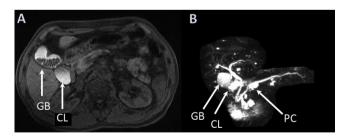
A) MRI: cystic lesion attached to the GB with lithiasis inside. B) MRI-cholangiogram. CL: biliary cystic lesion; GB: gallbladder; PC: pancreatic cystic lesions compatible with intraductal papillary mucinous neoplasm.
